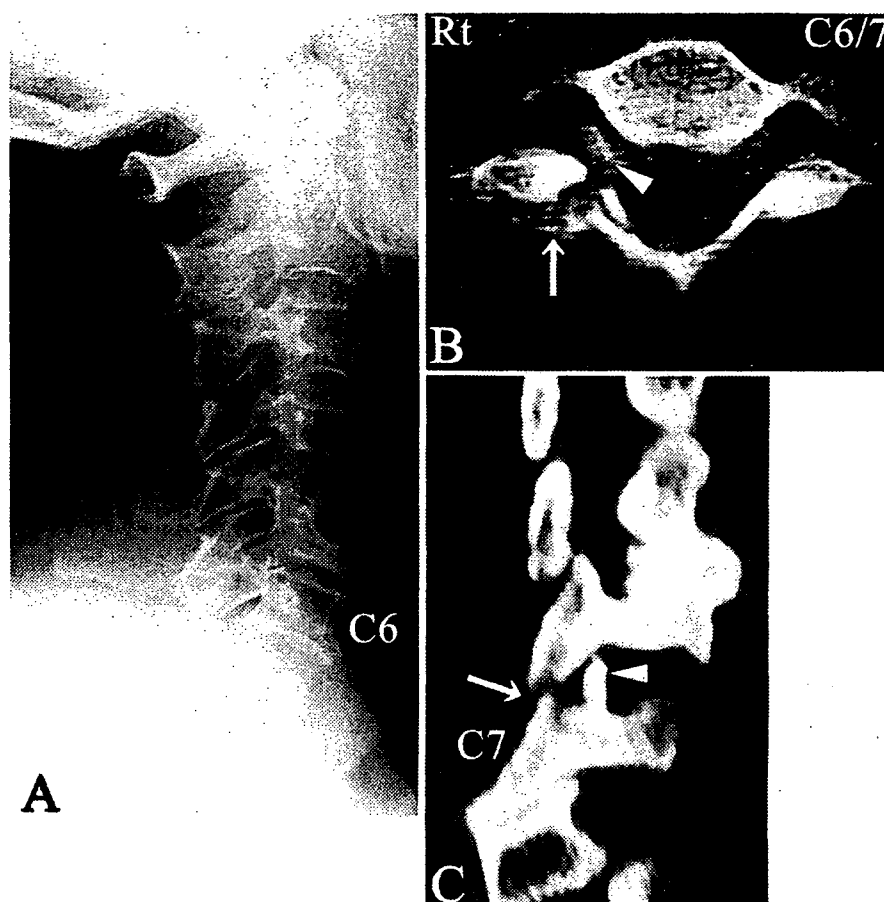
Preoperative imaging studies. A: Plain lateral radiograph showing anterior translation of the C-6 vertebra relative to the C-7 vertebra. B: Axial CT scan obtained at the C6-7 level demonstrating a fractured right facet joint (arrow) and bone fragments in the right neural foramen (arrowhead). C: Right parasagittal CT reconstruction revealing a fractured perched C6-7 facet joint (arrow) and bone fragments that migrated into the right C6-7 foramen (arrowhead).
